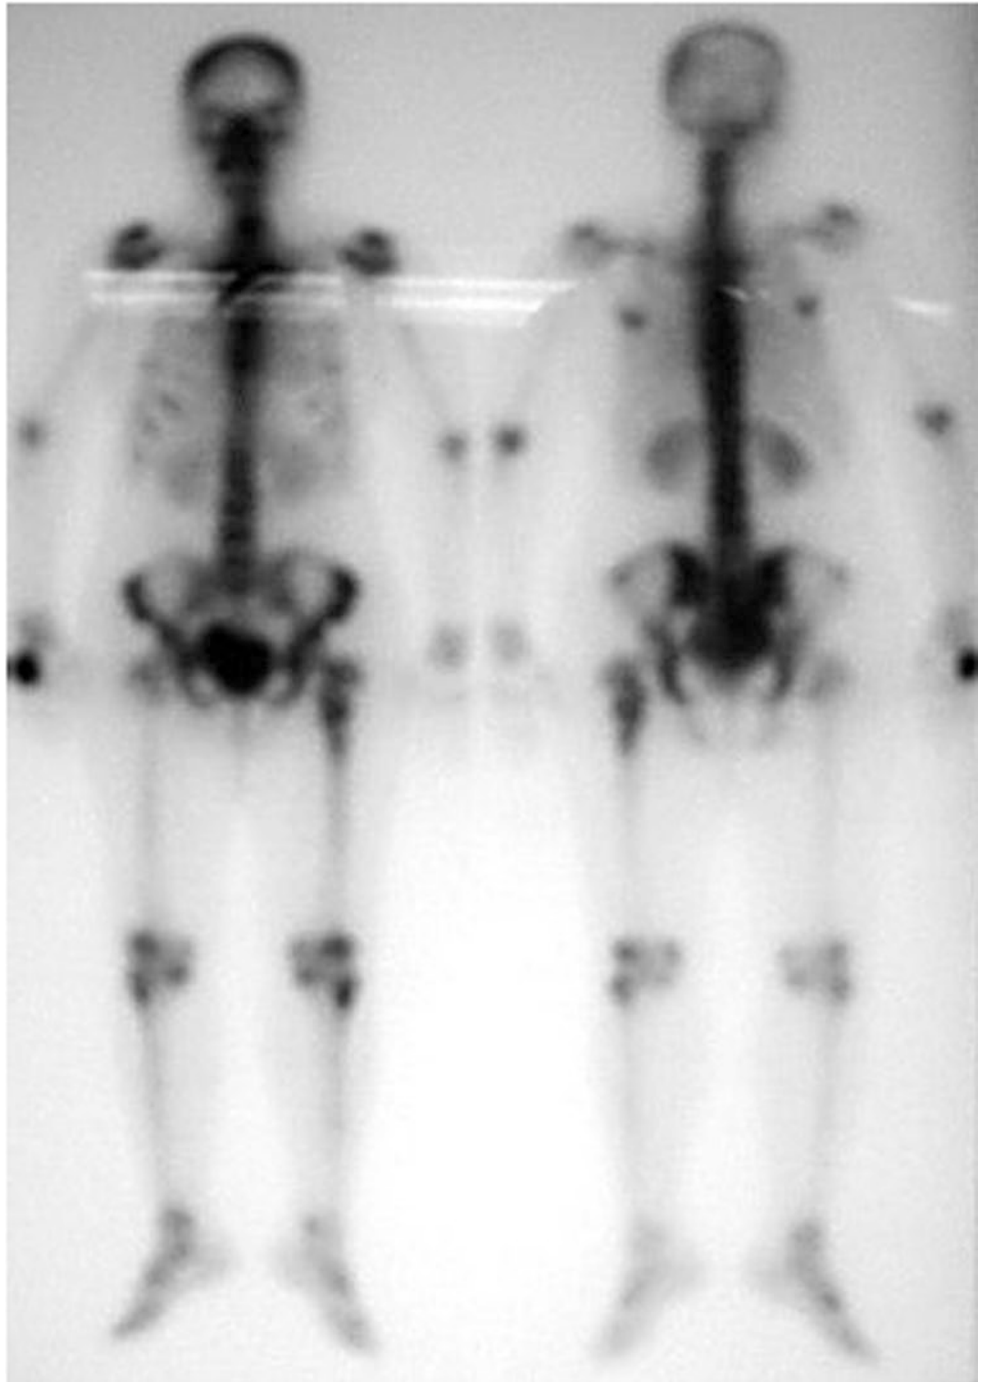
Bone scintigraphy showing a single bone lesion at the left proximal femur
